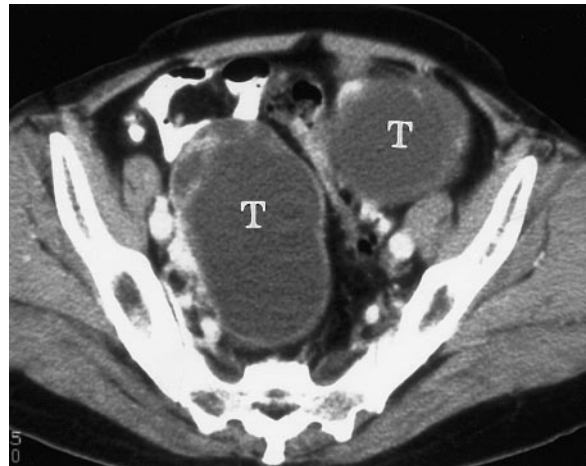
Bilateral serous cystadenocarcinomas in a 50-year-old woman. Contrast-enhanced CT scan shows bilateral ovoid tumors (*T*) with some septa and mural nodules.
